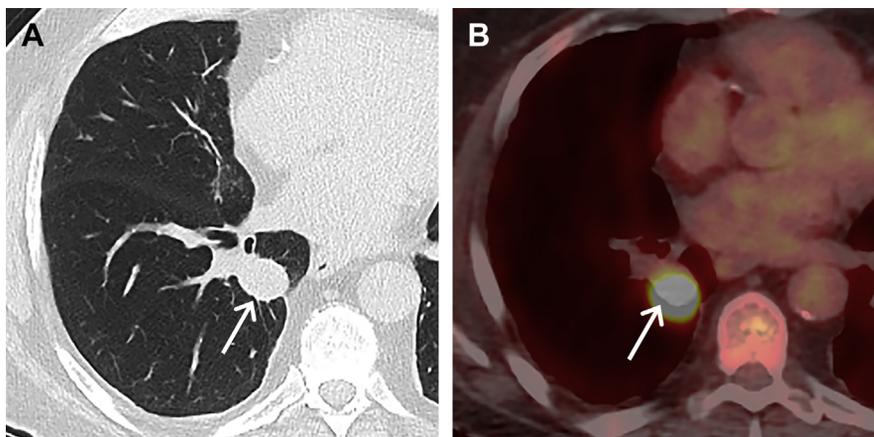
(A) Baseline axial LDCT of a 71-year-old man shows a 14-mm nodule (*arrow*) in the right lower lobe with irregular margins. Based on v1 of Lung-RADS, the examination was assigned an overall category of 4X, and diagnostic chest CT, FDG-PET/CT, and/or tissue sampling were suggested as possible methods of further management. (B) Fused axial FDG-PET/CT demonstrates increased FDG uptake in the nodule, which was highly suggestive of malignancy. CT-guided biopsy revealed non-small cell lung cancer.
